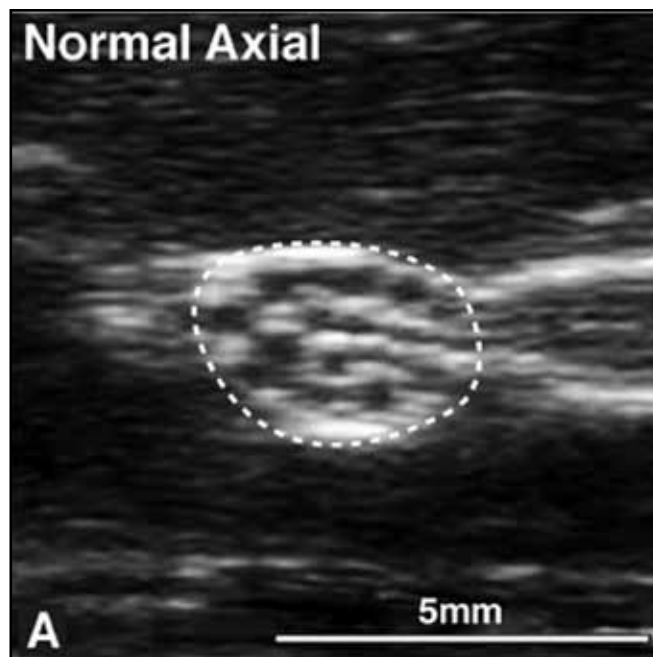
True entrapment of the peroneal nerve. A 25 year old male presented with a one week history of peroneal neuropathy with no precipitant. Ultrasound showed focal enlargement of the nerve just proximal to the entry of the fibular tunnel with sharp transition of nerve caliber back to normal within the fibular tunnel.
